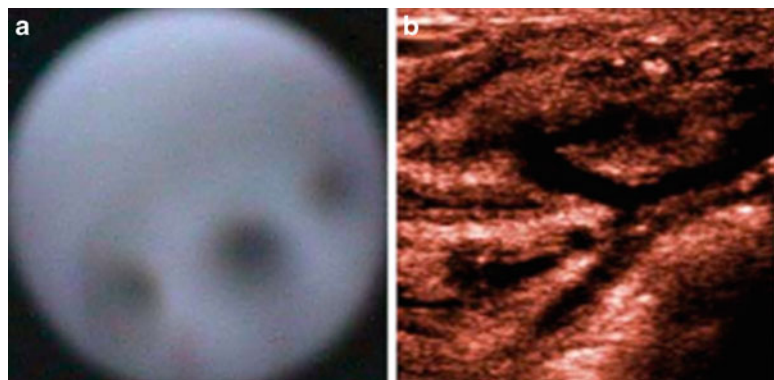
(a) Ductoscopy showing a trifurcation. (b) Ultrasound confirmation of the trifurcation
